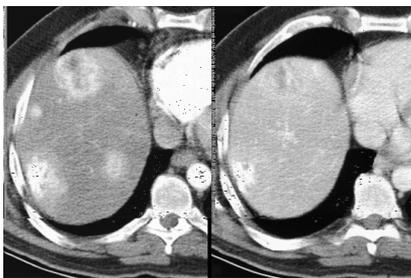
Hypervascular metastasis. Using single slice helical CT, the early hepatic arterial dominant phase (HADP) shows the lesions well but they are less well seen during PVP in the image on the right.
